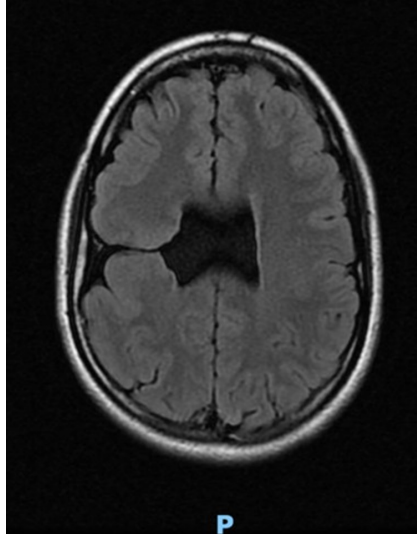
Simple MRI of the brain, axial slice, showing open-lip schizencephaly.
